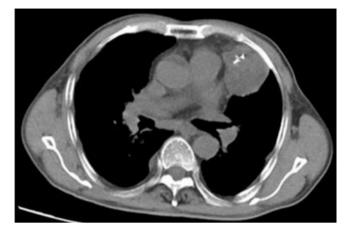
A 55-year-old woman with thymic squamous cell carcinoma. Chest CT showed a large area of necrosis and calcifications within the lesion invading into the superior vena cava (red arrow)
